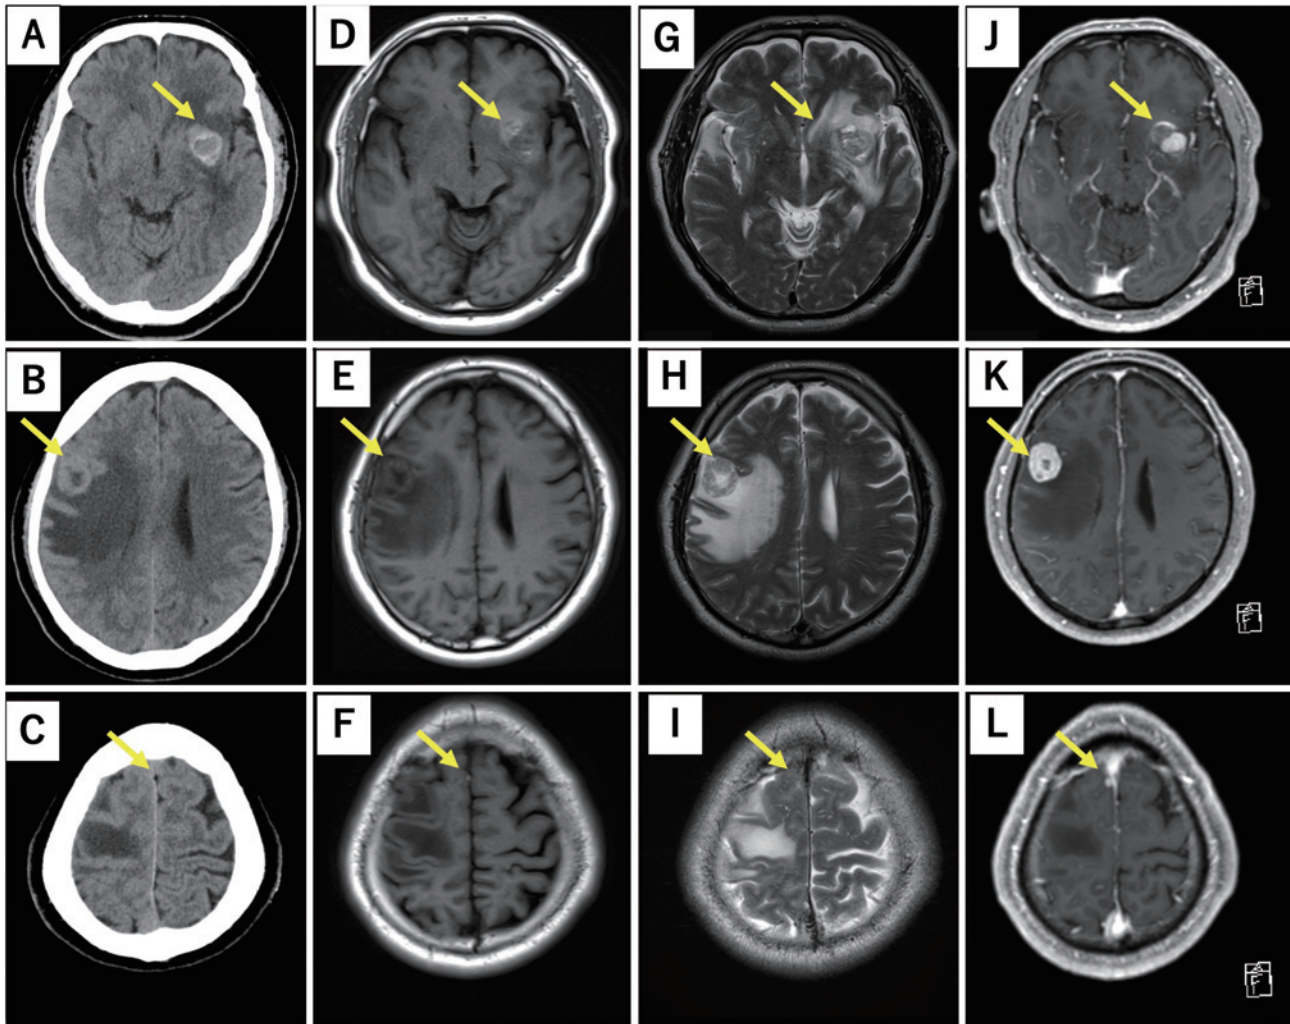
Preoperative brain imaging. A plain computed tomography (CT) scan showed a 20-mm high-density lesion in the left basal ganglia (A), a 25-mm mass located primarily within the right inferior frontal gyrus (B), and a 5-mm mass in the right frontal lobe facing the cerebral falx (C). In the magnetic resonance imaging (MRI), all lesions showed isointense on a T1-weighted image (T1WI) that was enhanced by gadolinium and hyperintense on a T2-weighted image (T2WI) (D–L). All lesions were associated with strong edematous alterations, especially in the right frontal lobe lesion (G–I).
